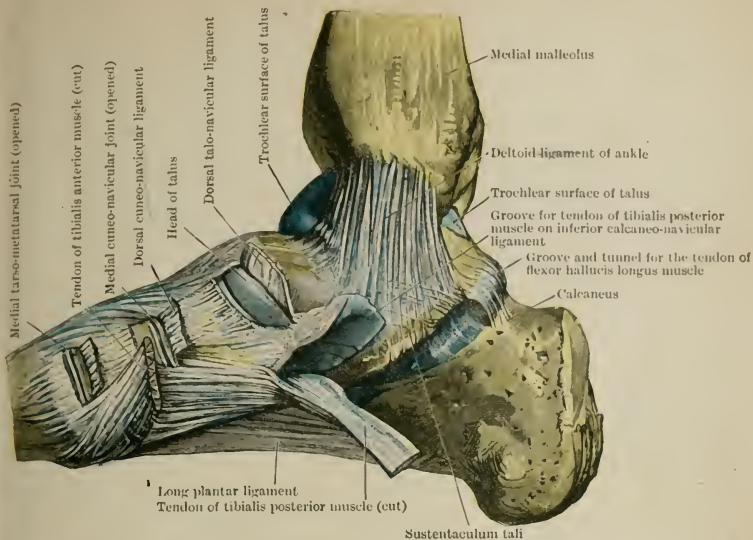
ANKLE AND TARSAL JOINTS FROM THE TIBIAL ASPECT.
